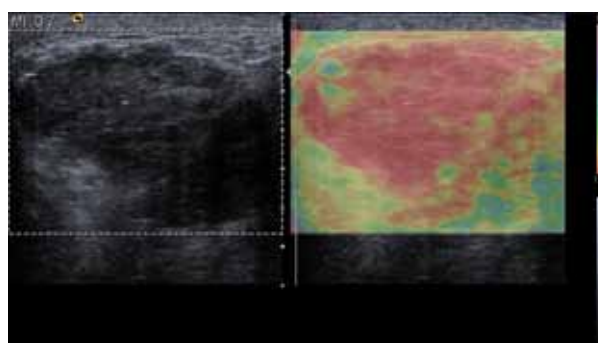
A 38 Year-old-woman with Chronic Inflammation. Sonographically, and UE (score 4) imaging misdiagnosed as a breast cancer
